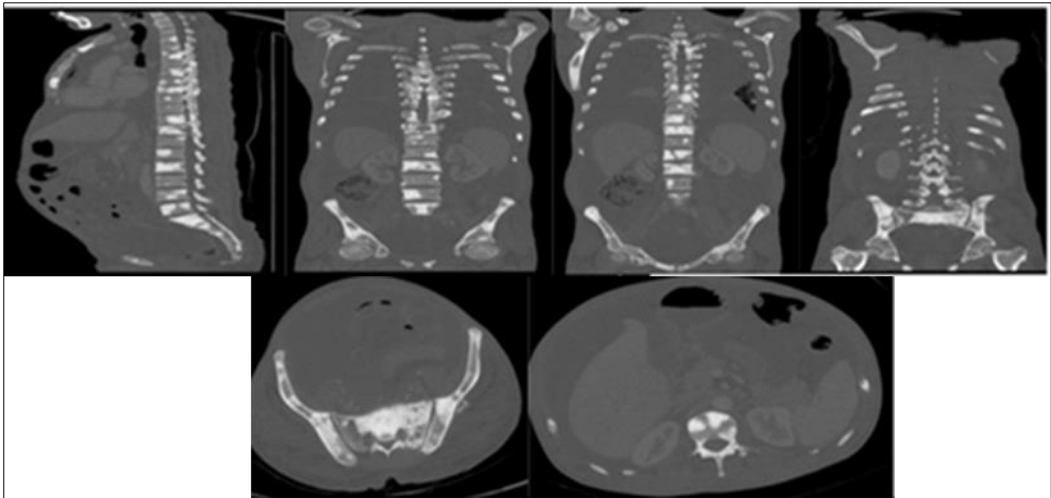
CT Bone Window revealing multiple sclerotic lesions
